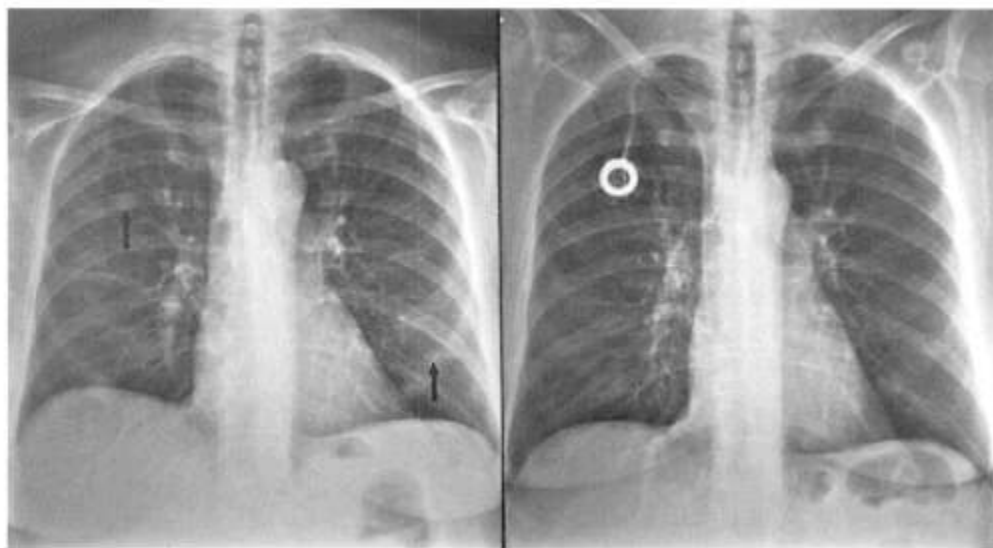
(Left) Chest X-ray on 13 July 1994 reveals bilateral metastatic lung nodules (arrows). (Right) Chest X-ray on 22 December 1994 reveals resolution of the lung nodules.
